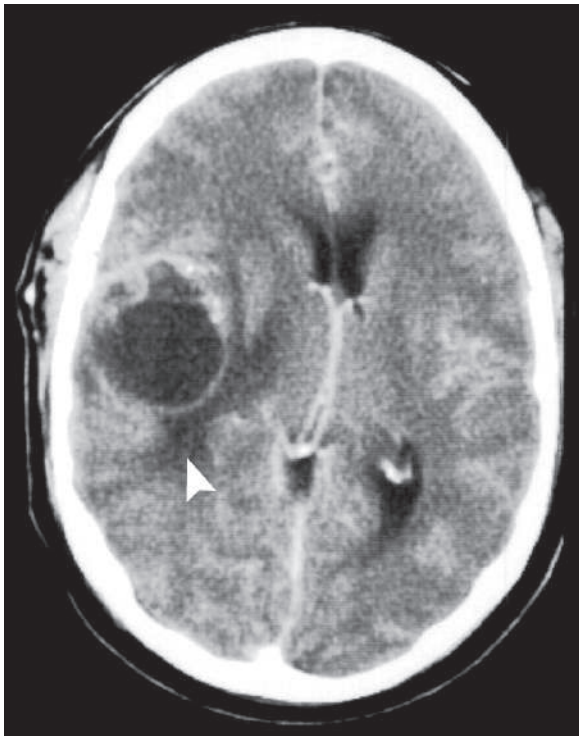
Axial postcontrast brain CT shows right temporal abscess with thin rim enhancement and vasogenic edema (*arrowhead*) that exerts mass effect over the anterior horns of the lateral ventricles
